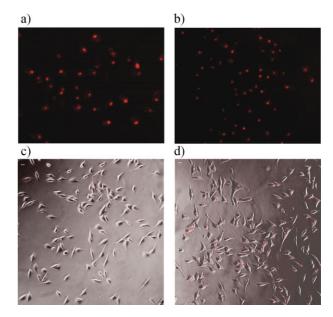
Role of lipid rafts and clathrin on QD internalization and dotof-dots formation in PC3-PSMA cells. PC3-PSMA cells were treated a) with or b) without the cholesterol extracting agent, methyl-βcyclodextrin for evaluating the role of lipid rafts, and c) with or d) without the clathrin inhibiting agent, chlorpromazine for evaluating the role of clathrin on the uptake of QDs.
